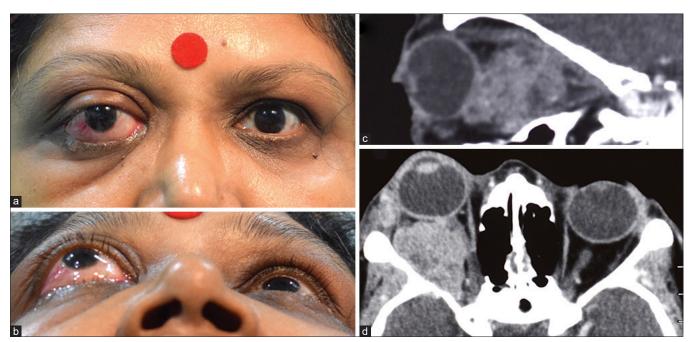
A 52-year-old female presenting with gross proptosis of the right eye (a), more evident in the worm's eye view (b). CT scans show the intraconal extent of the mass (c). Axial slice showing the diffuse irregular iso-to-hyper dense mass infiltrating the lateral rectus and displacing the optic nerve medially (d)
